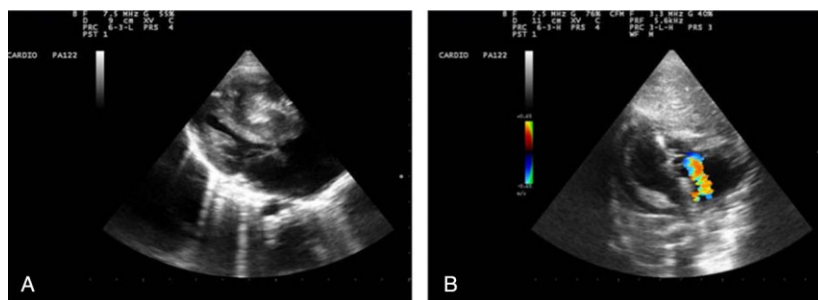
(A) Echocardiographic appearance of the patient: massive mass in right ventricle protruding into right atrium through the tricuspid annulus. (B) Doppler image shows that there are no masses in the heart and second degree tricuspid regurgitation after the resection.
